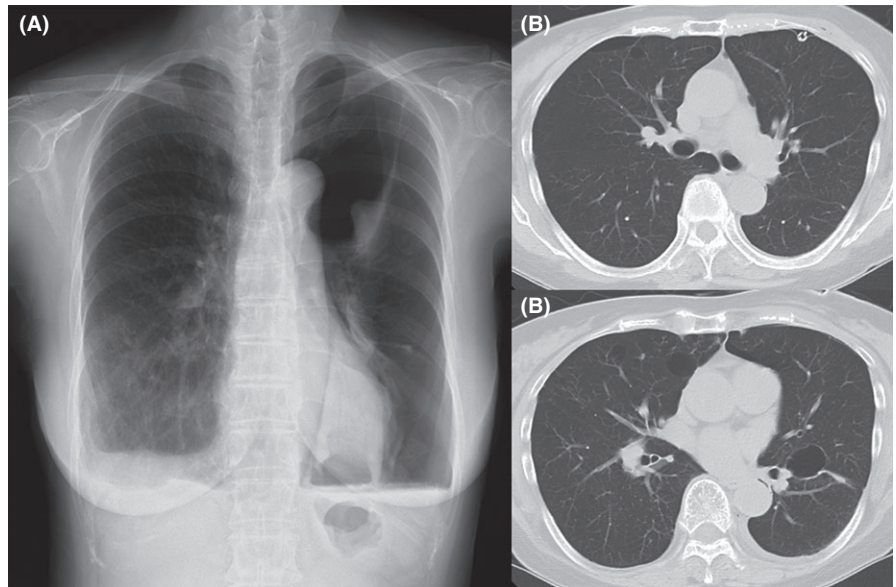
A, Chest radiograph on presentation; B, chest CT after tube thoracostomy on recurrence of left pneumothorax
